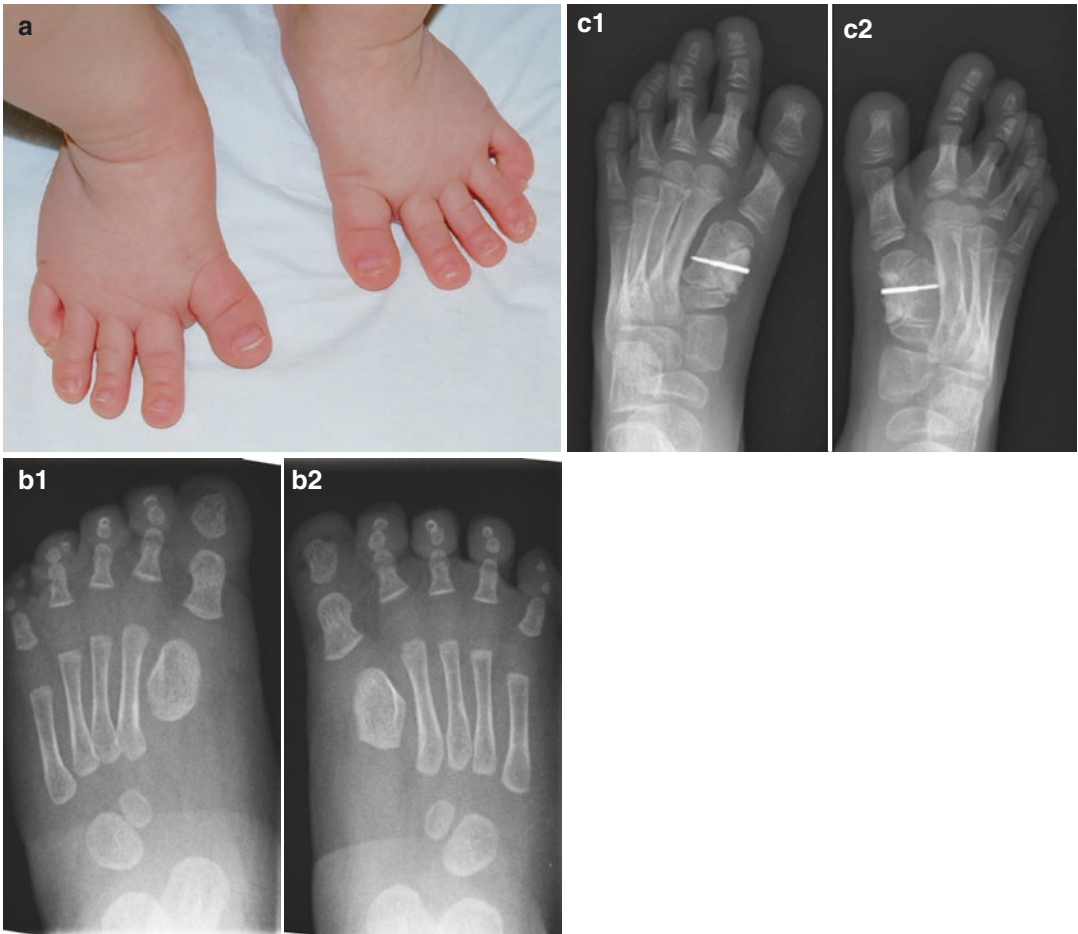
(a) Bilateral hallux varus in a 1.5 year old child. (b1, b2) Foot X-rays (the same child as in a). There is a severely shortened and broad bilateral first metatarsal.
